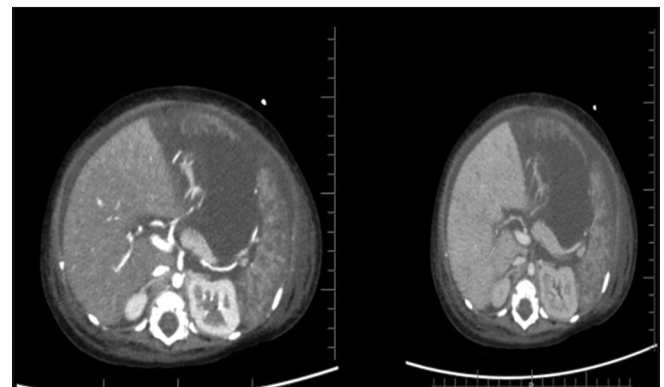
Computed tomography abdomen reveals enlarged spleen with splenic microinfarct and gross ascites
